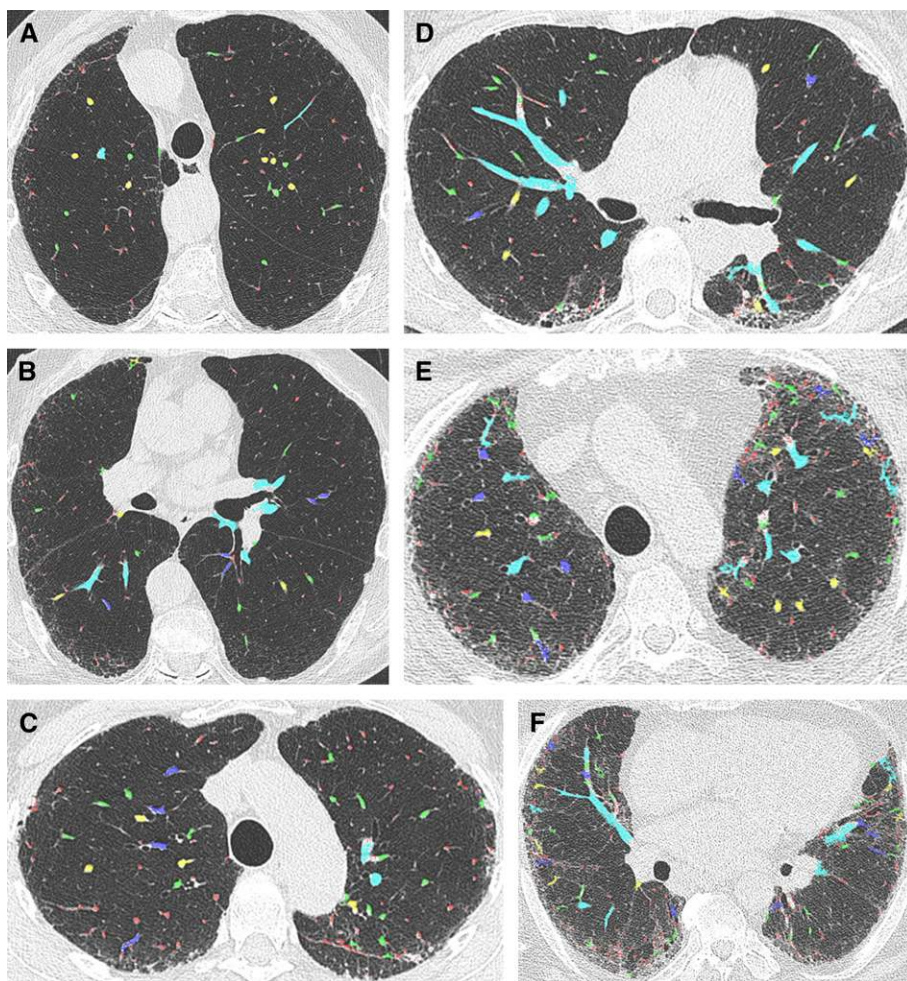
Color overlay computed tomographic images demonstrating CALIPER (Computer-Aided Lung Informatics for Pathology Evaluation and Rating software) vessel-related structures (CAL VRSs) of different sizes in the upper and middle lung zones in three patients with idiopathic pulmonary fibrosis with varying degrees of disease severity. (A and B) A 78-year-old male ex-smoker (DL_{CO} , 69.7% predicted) demonstrates mild reticulation at the anterior and posterior aspects of the lungs. (C and D) A 56-year-old female ex-smoker (DL_{CO} , 57.1% predicted) demonstrates coarse reticulation most marked in the apical segments of the lower lobes bilaterally. (E and F) A 68-year-old male ex-smoker (DL_{CO} , 27.5% predicted) has more extensive reticulation in the lung periphery and at the lung bases. As fibrosis extent increases, so too does the CAL VRS score within the lungs. CAL VRS size key: red = $< 5 \text{ mm}^2$; green = 5–10 mm^2 ; yellow = 10–15 mm^2 ; dark blue = 15–20 mm^2 ; light blue = $> 20 \text{ mm}^2$.
